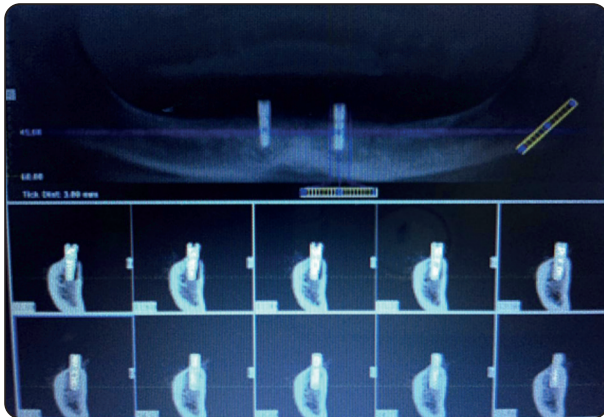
CBCT used to measure the height of the bone between two reference positions.
